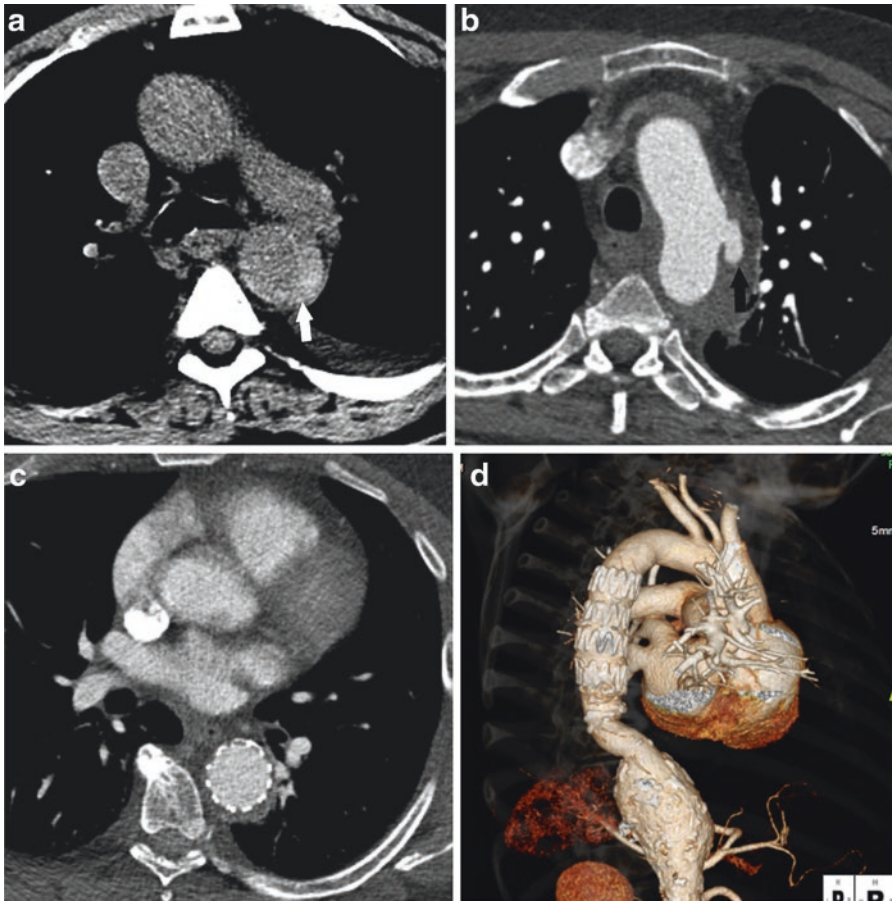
63-year-old male with uncontrolled hypertension, presenting for a noncontrast CT thorax for preoperative planning prior to a CABG procedure. Noncontrast image (a) demonstrates crescentic high attenuation in the wall of the descending aorta (*white arrow*), consistent
